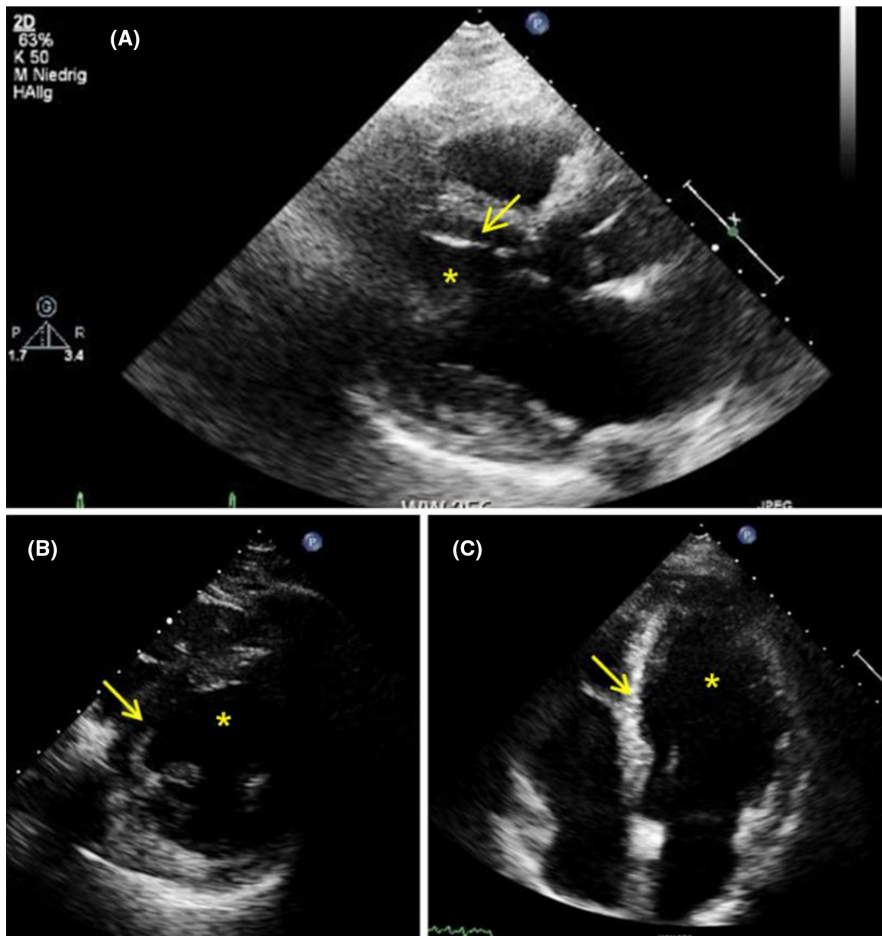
Echocardiography examples. (A) parasternal long axis; (B) parasternal short axis; (C) apical view. Left ventricle (asterisk), ventricular septum (arrow) with left ventricular hypertrophy
